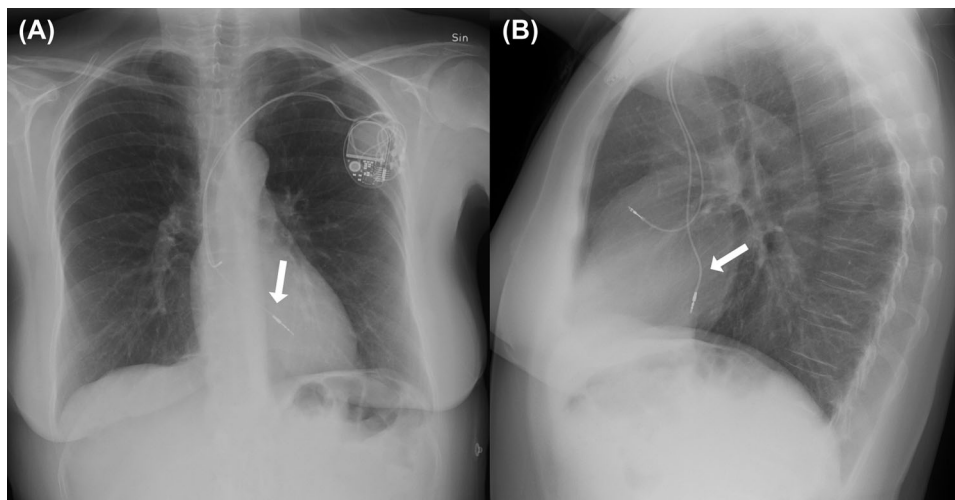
Chest X-ray postero-anterior view showing ventricular lead (arrows) superior to usual course (A) and lateral view showing the posteriorly directed ventricular lead (B), indicating position in the left ventricle
